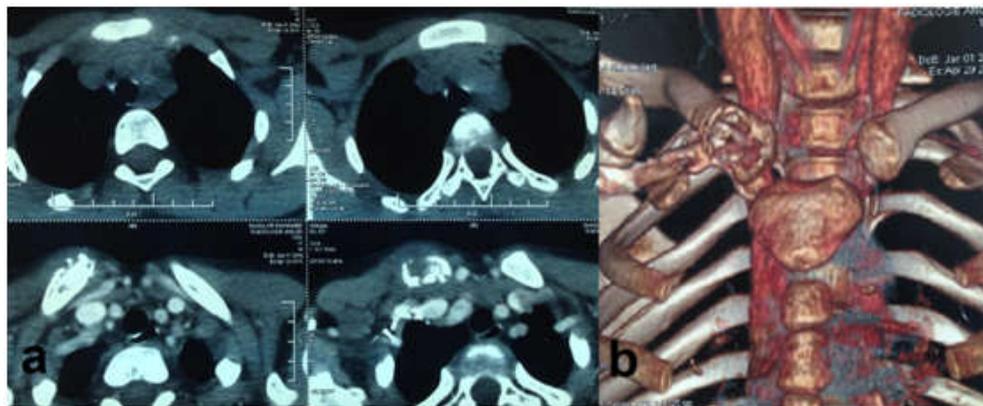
a. CT objectifying the absence of associated pulmonary involvement, b. 3D reconstruction objectifying the isolated clavicular lytic lesion
